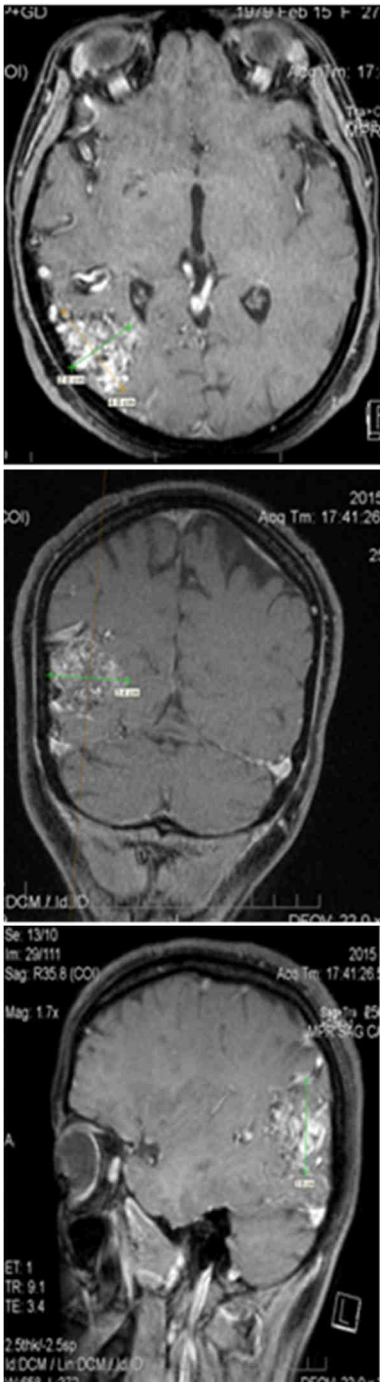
MRI scan, T1 with contrast image
